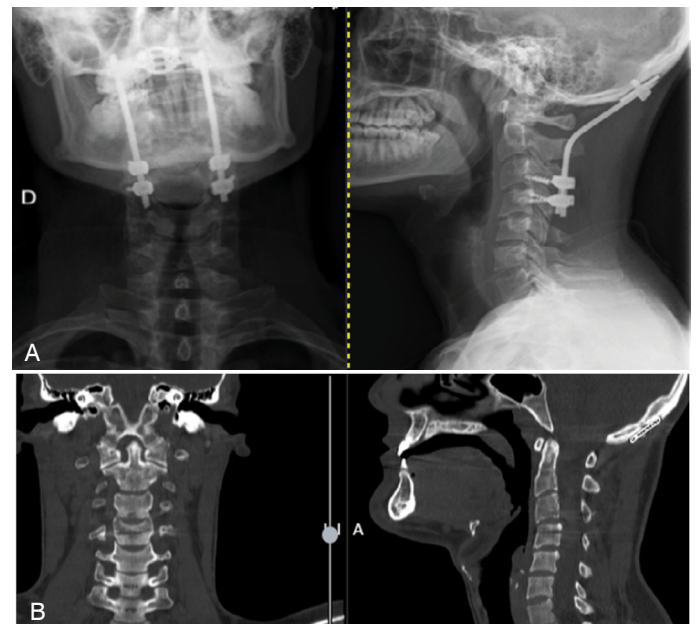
X-ray (A) and CT scan (B) taken two years after the trauma.
